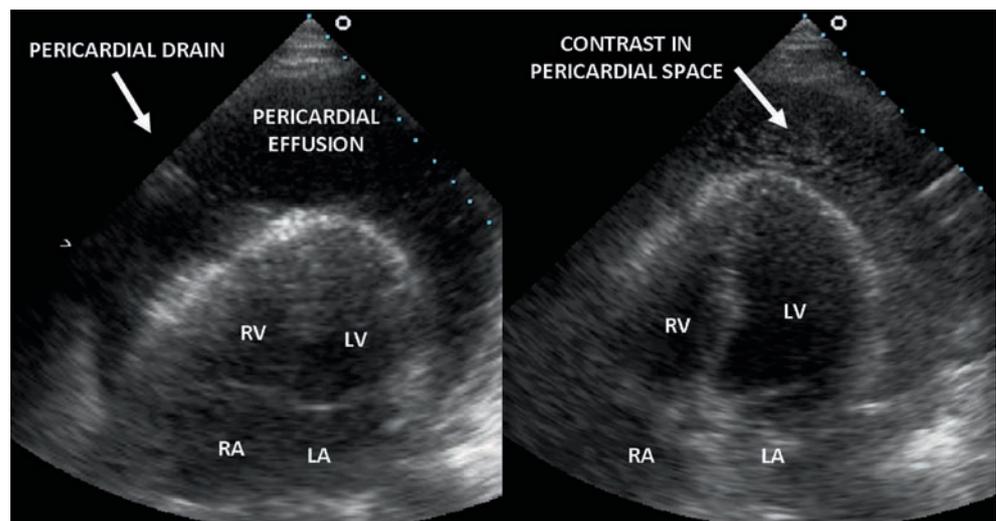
Apical four-chamber echocardiography views acquired during pericardiocentesis. In (a) a part of the pericardial drain is just visible, and in (b) agitated saline contrast has been injected down the pericardiocentesis needle to confirm position of the needle within the pericardial space. Images courtesy of Echocardiography Department, John Radcliffe Hospital, Oxford
